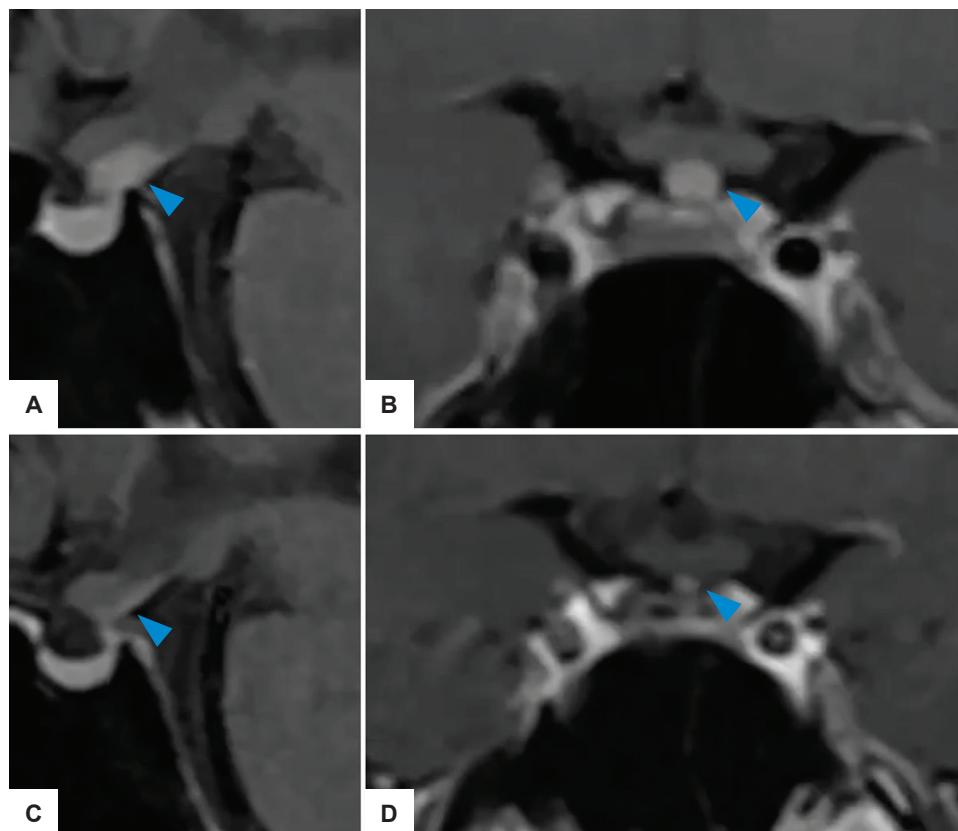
Magnetic resonance imaging of hypothalamic-pituitary regions (contrast-enhanced T1-weighted) during follow-up (A-D). Pituitary stalk (*arrowheads*) was less thickened in 2017, measuring 5 mm (A, B) and the pituitary stalk diameter was further reduced in 2021, measuring 4.5 mm (C, D).
